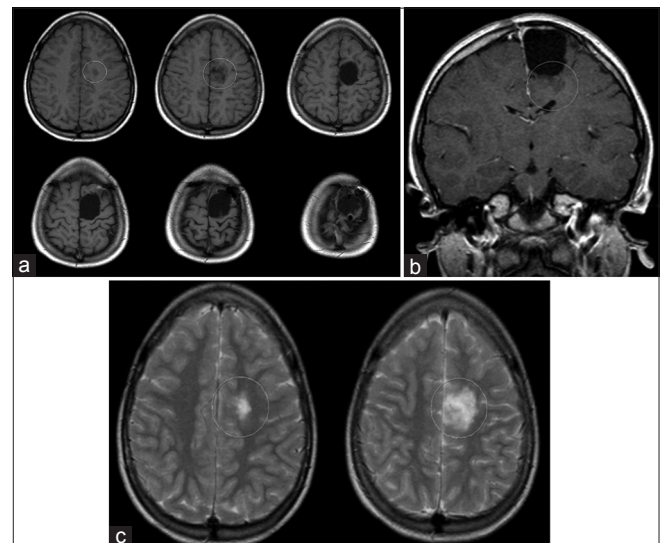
(a-c) Postoperative axial, coronal and sagittal SET1 (above) and axial T2 (below) MR images in January 2003 demonstrate a small amount of residual DNT tissue (thin graphic circle) at the inferior resection margin in the white matter extending to the left lateral ventricle
